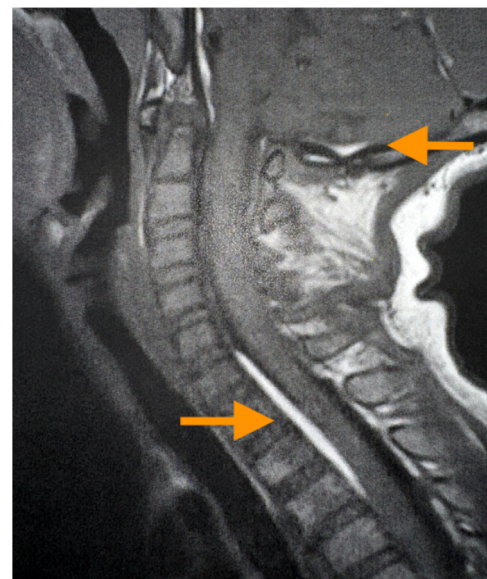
Sagittal view of magnetic resonance imaging of the neck with contrast demonstrating left cerebellar hemorrhage (upper arrow) with fifth cervical to second thoracic spinal extension (lower arrow).
